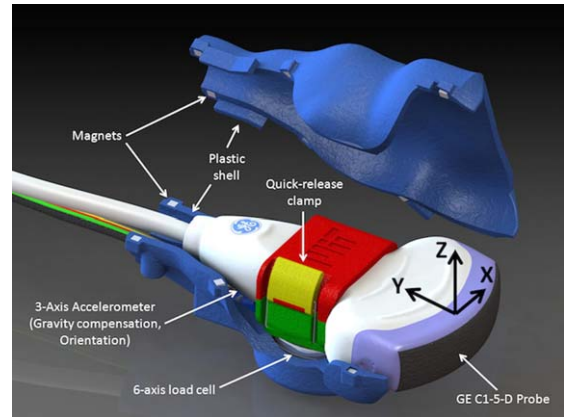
Rendering of the hand-held force-measuring ultrasound probe, which attaches to a GE C1-5D abdominal probe, and measures the relative forces applied between the ultrasound probe and patient in the X, Y, and Z axes. Force is predominantly applied along the Y-axis.
